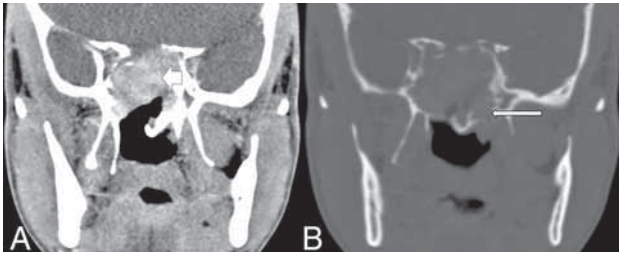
GCG of the sphenoid bone. A, Contrast-enhanced CT of the skull base shows a lobulated, enhancing mass in the sphenoid sinus (*short arrow*). B, On the bone window, the mass expands the sphenoid bone and there are multiple foci of a cortical breach (*long arrow*). Note the absence of matrix mineralization in the lesion.
